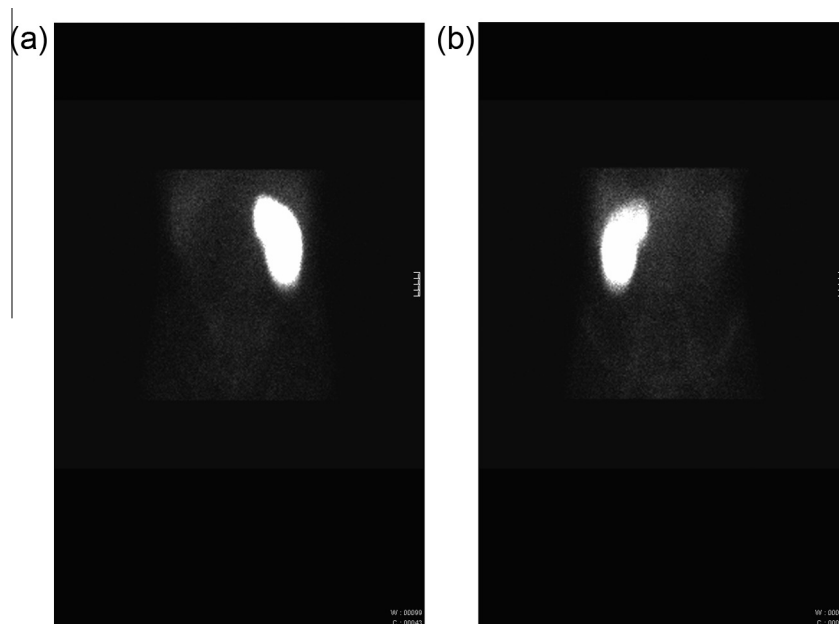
The fifteen-year-old boy with recurrent pelvic pain has undergone scintigraphy examination: The image (a) shows the absence of left kidney from anterior view, (b) as same as the image a, the posterior view of the scintigraphy confirms the absence of the left kidney.
